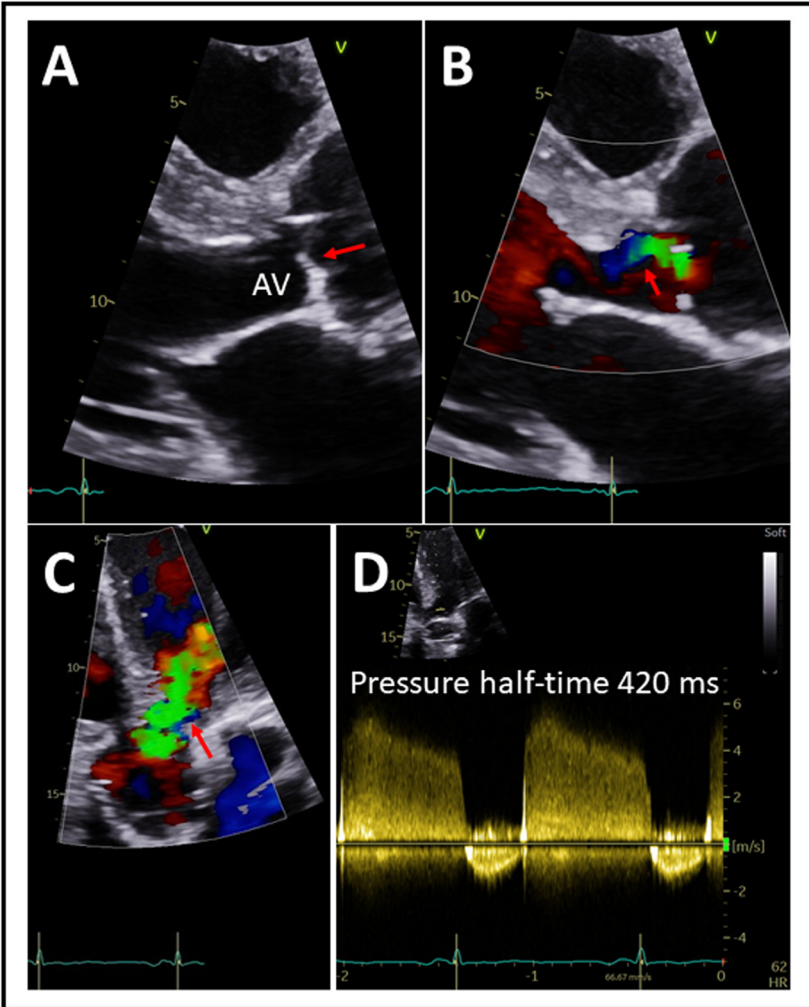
Echocardiographic images of a young patient with moderate aortic regurgitation. On auscultation a grade 2-3 diastolic murmur of blowing character on aortic valve points of the chest wall could be heard. A and B display parasternal long-axis views and C apical 5-chamber view with a slightly calcified aortic valve (AV) and an abnormal motion of non-coronary cusp (probably prolapse) (A, red arrow) leading to an eccentric regurgitant jet (B-C, red arrows), with a pressure half-time of 420 ms (D). Color version of figure is available online.
